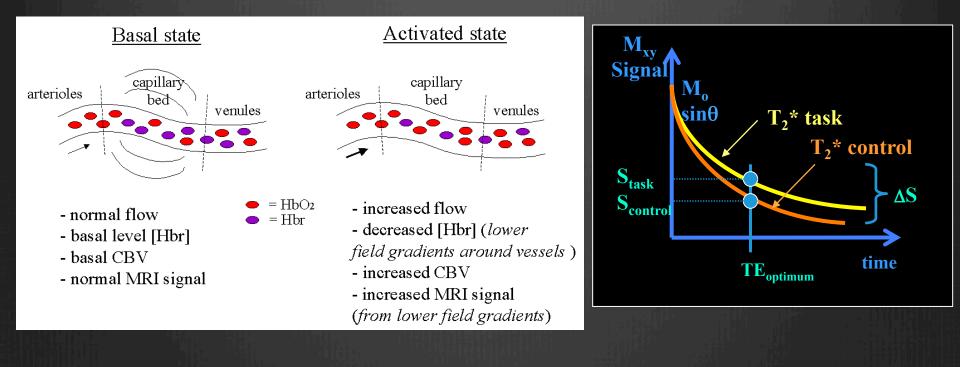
Figure Source, Huettel, Song & McCarthy, 2004, Functional Magnetic Resonance Imaging
